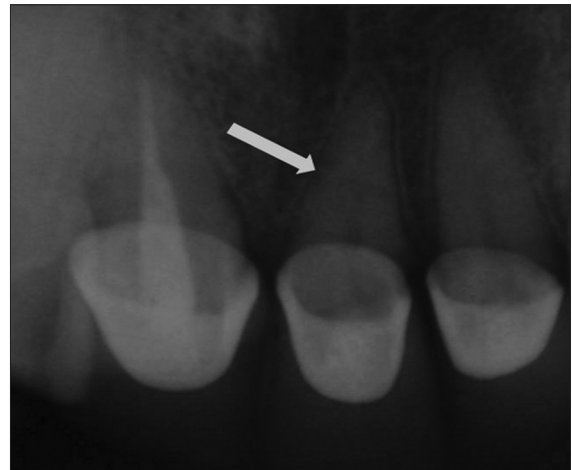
Radiographic view of root fracture of the maxillary left central incisor
